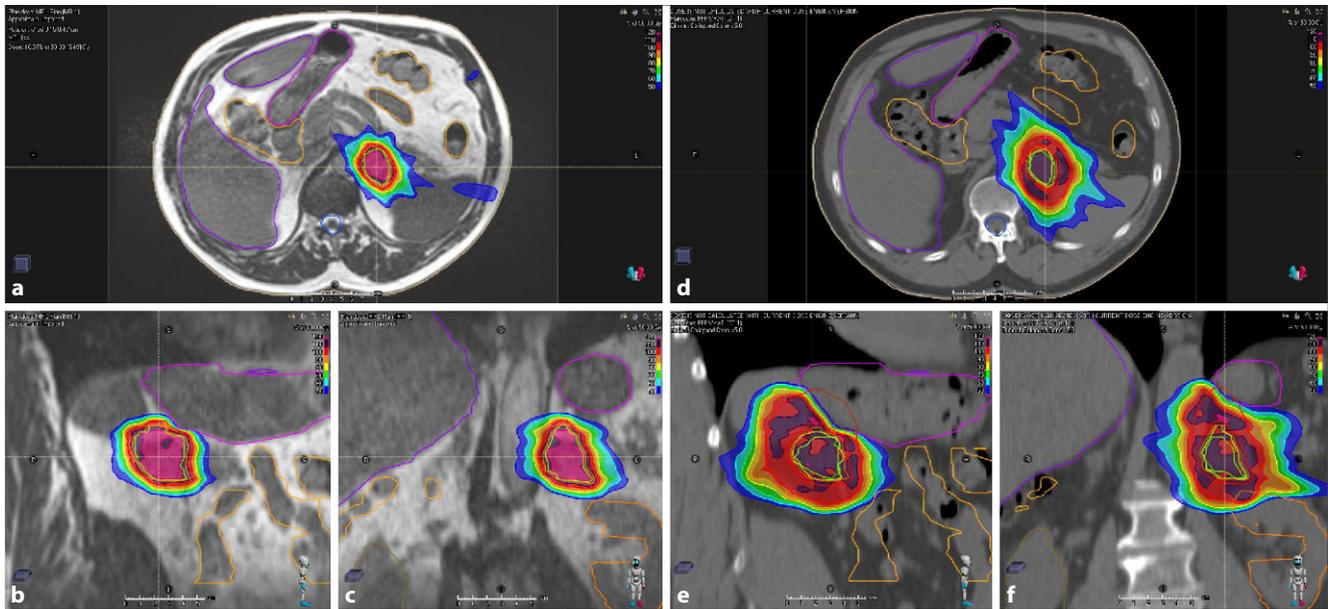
▲ Treatment plan for patient 3 (adrenal gland metastasis) as applied at the magnetic resonance (MR)-Linac using gated treatment in breath-hold (a–c: axial, sagittal and coronal images). Retrospectively generated computed tomography-based plan with internal target volume (ITV) showing a larger treatment volume compared with the MR-Linac plan (d–f: axial, sagittal and coronal images). In this case, the ITV extends into the right lung in order to geometrically cover the entire area of tumor location during breathing motion
